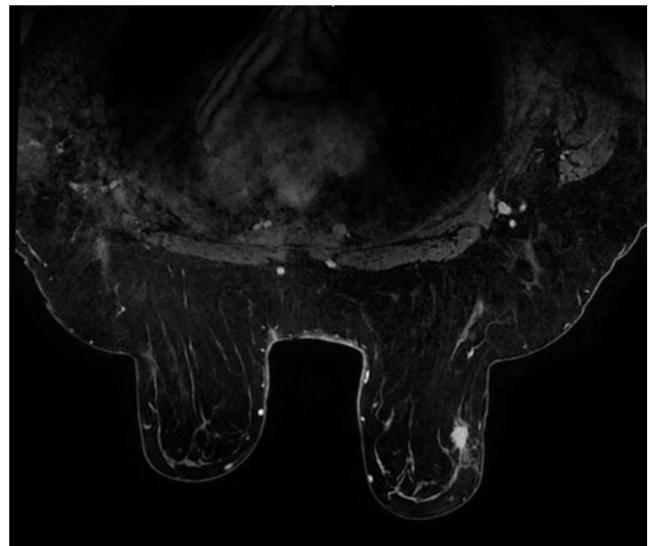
MRI showed an irregular mass with distortion; it has an irregular enhancement at the margins. Multiple benign looking axillary lymph nodes are seen with preserved fatty hilum.
